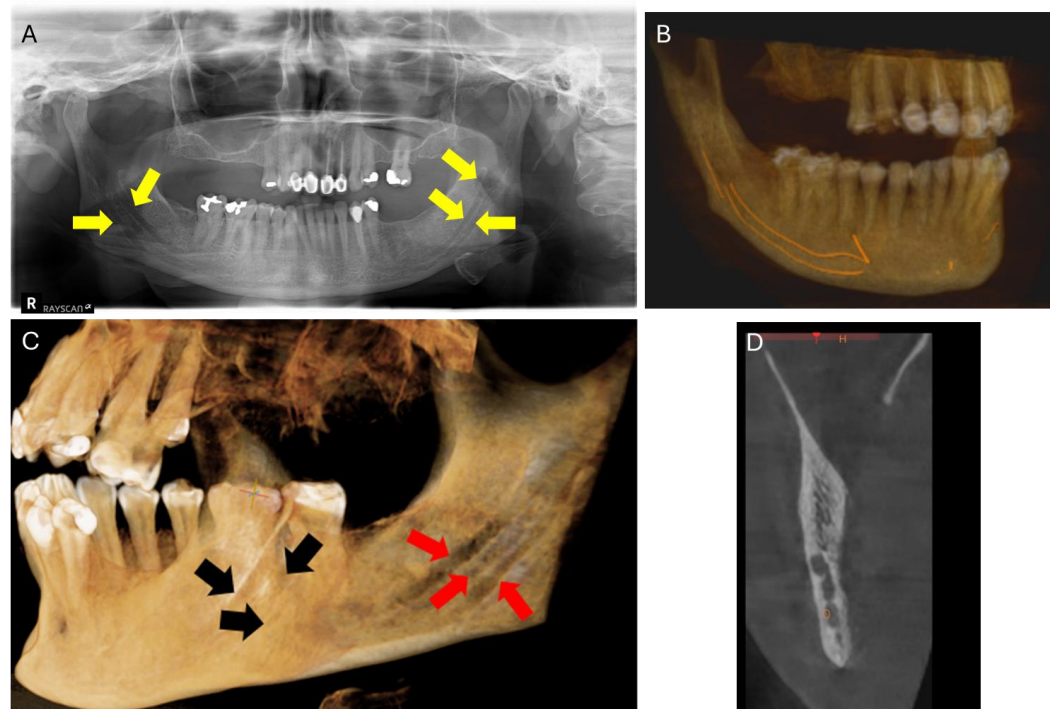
A. Radiographic image showing bilateral trifid mandibular canal. This variation in the mandibular canals underscores how intricate and diverse mandibular canal structures can be. B. The cone beam computed tomography (CBCT) image highlights the trifid mandibular canals. C. On the right side of the image, red arrows clearly point out the three distinct branches of the trifid mandibular canal. On the left side, black arrows indicate the three branches of the trifid mandibular canal, providing precise identification of each branch. D. An orthoradial slice on the right side of the mandible displaying a trifurcated root canal. The image clearly reveals three distinct branches of the root canal, indicating a complex anatomy.
